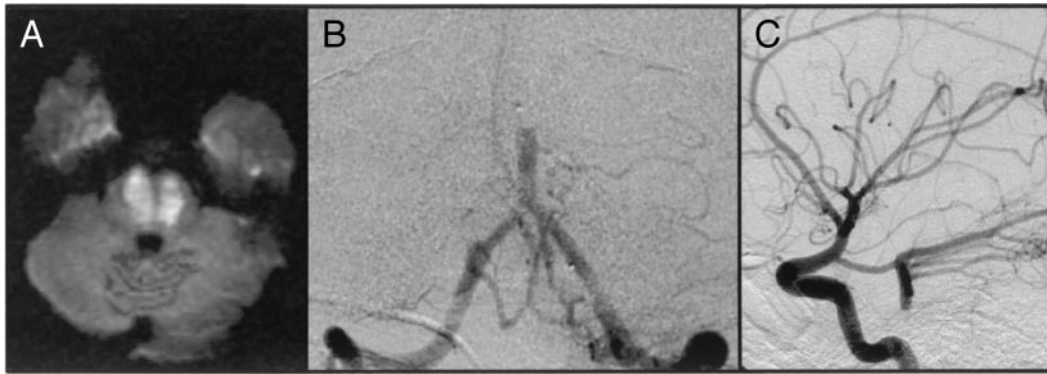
Initial imaging. A, Diffusion-weighted MRI demonstrates bilateral pontine ischemia. B and C, angiography demonstrates midbasilar occlusion with filling of the top-of-the-basilar from the anterior circulation.
